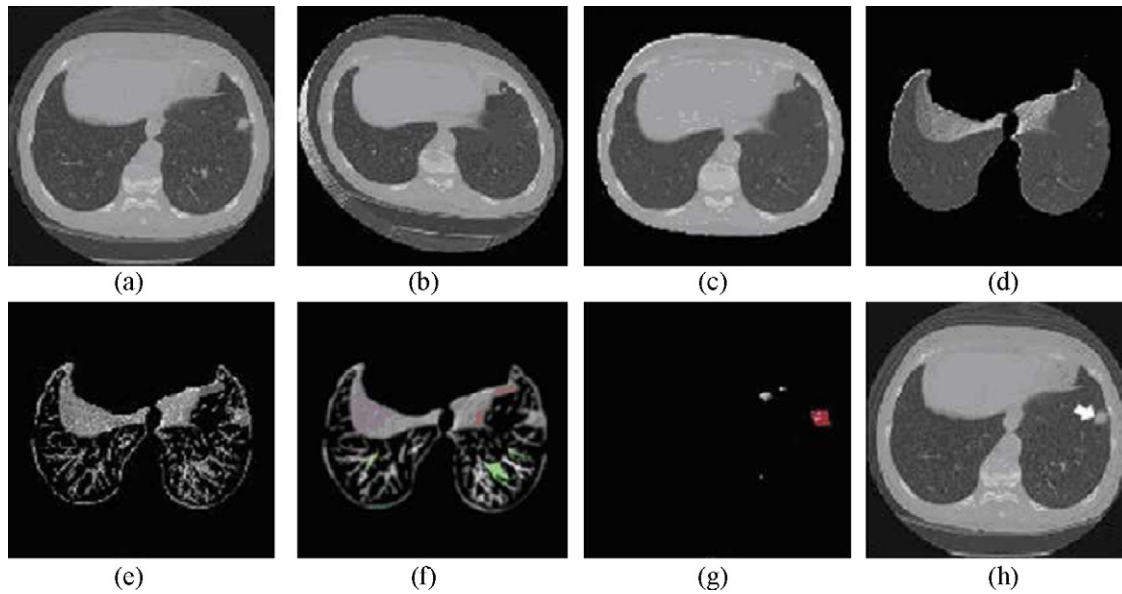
Case study – successful detection. (a) and (b) are 2D and 3D visualization of the original CT exam. (c) Eliminates of all artifacts external to the patient's body. (d) Removes thorax just remaining the parenchyma and shows the reconstructed parenchyma. (e) 3D Visualization of the remaining structures after threshold application. (f) 3D Visualization of the structures after tubular elimination. (g) Shows lung candidates before SVM classification. (h) Shows correctly detected nodule in the original CT.
